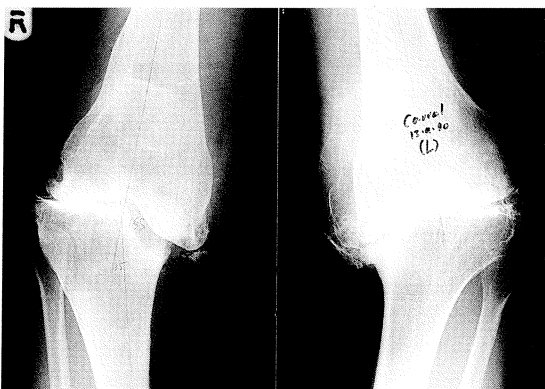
AP X-ray of both knees: Large defect in both medial tibial condyles, with severe bilateral osteoarthritis.
